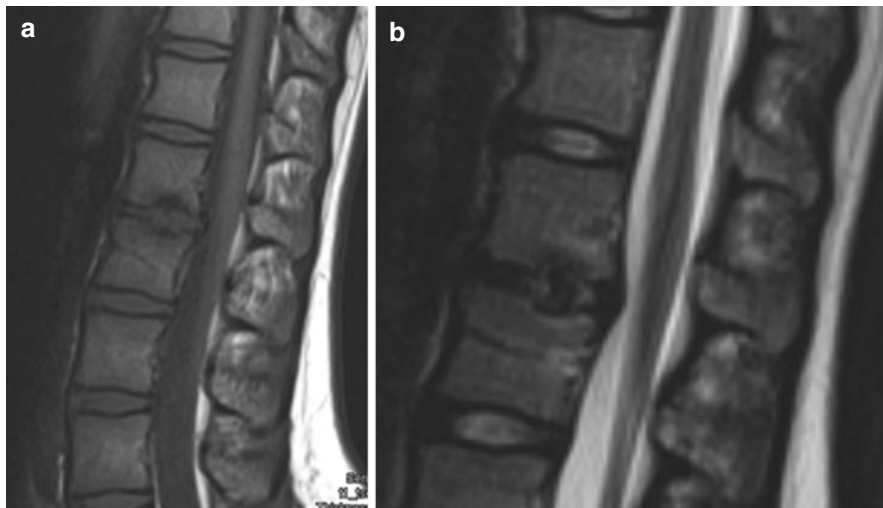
Schmorl's node and disc degeneration (lumbar spine, L1-L2 space) (a: MRI T1, b: MRI T2)
